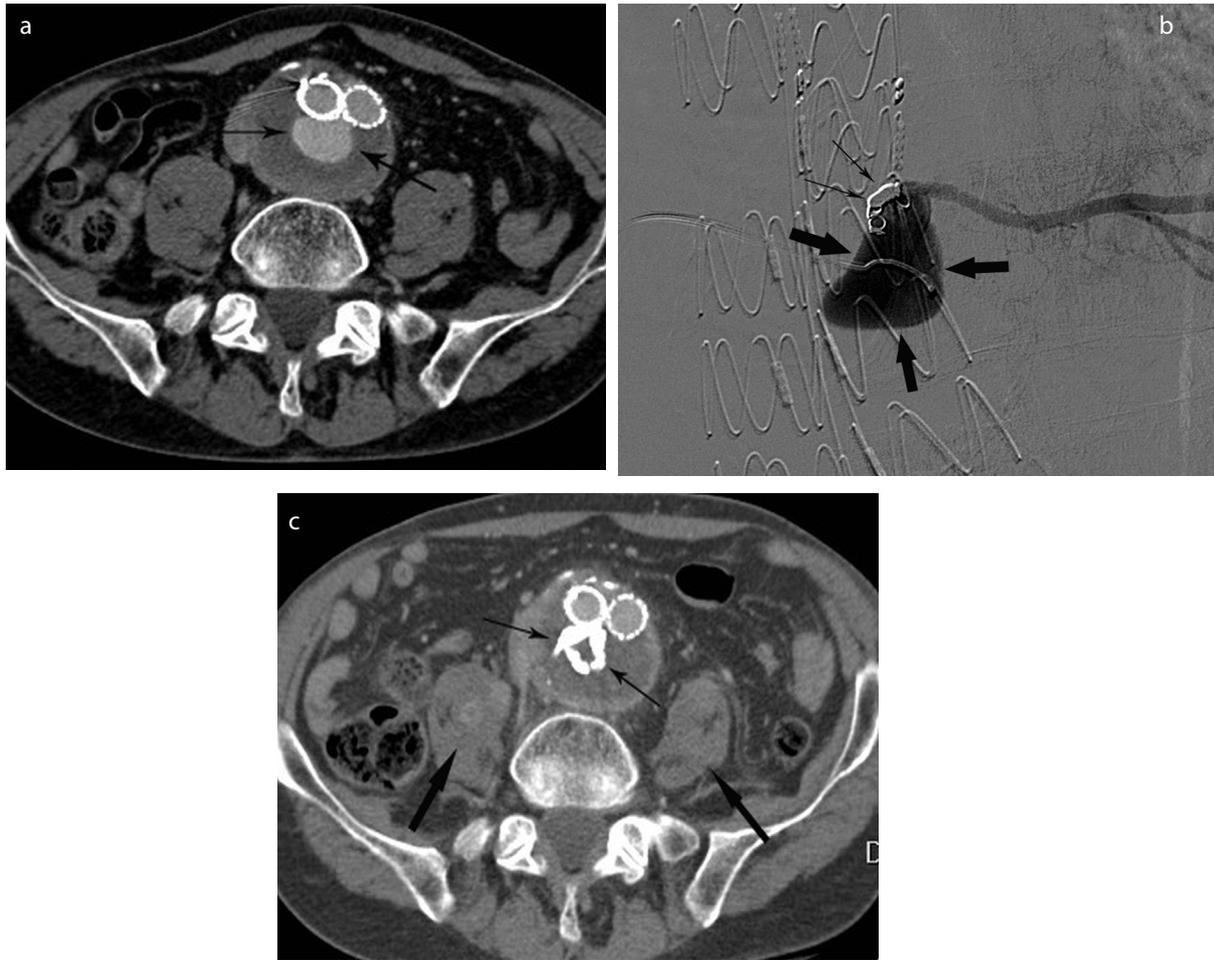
(a) Venous phase, contrast-enhanced axial computed tomography (CT) image in a patient with a growing aneurysm sac and a sharply delineated type 2 endoleak (small black arrows) posterior to the endograft limbs; the patient was referred for translumbar direct puncture and embolization of the type 2 endoleak. (b) Digital subtraction angiography of the nidus (large black arrows) of the type 2 endoleak after direct translumbar puncture. Also, note the coils (small black arrows) deployed in the proximal left fourth lumbar artery. (c) Follow-up contrast-enhanced CT scan nine months after translumbar endoleak embolization demonstrating the cast of glue (mixture of embucrylate and ethiodized oil) (small black arrows) completely filling the type 2 endoleak. Also note the contrast-enhancing foci in both psoas muscles (large black arrows), suggestive of psoas abscesses.
